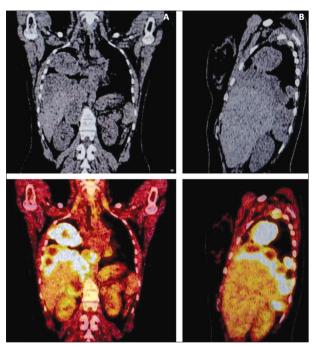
A – coronal; B – sagittal computed tomography, fused positron emission tomography/computed tomography images of elevated anterior part right hemidiaphragm after upper-right lobectomy
